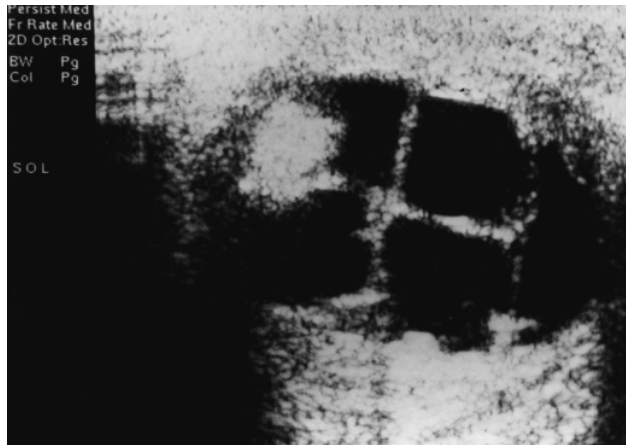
Ultrasonography of the left testis shows a huge mass including cystic, solid, and calcified areas.
